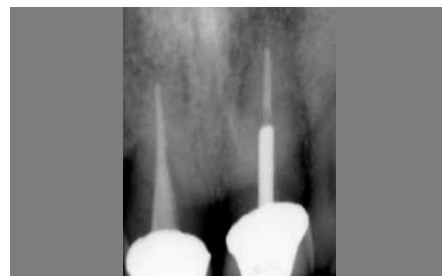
Initial radiograph. Notice that the adjacent central incisor has endodontic and post therapy.
